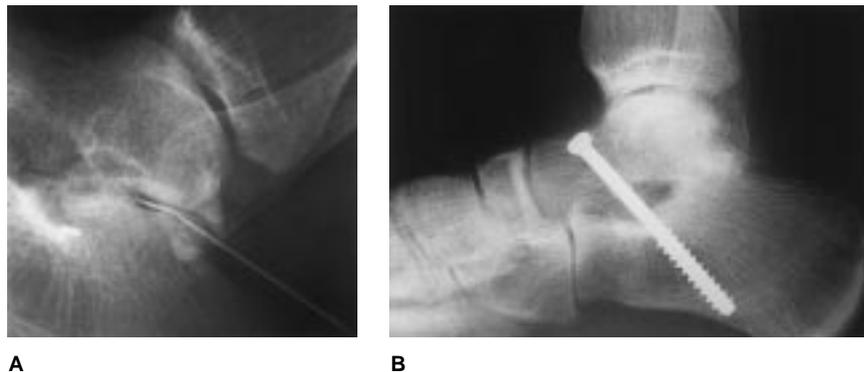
A, Fluoroscopically controlled anesthetic injection of the subtalar joint. The patient reported complete pain relief after the injection. B, A lateral radiograph demonstrates osseous union 1 year after a subtalar arthrodesis. The patient had excellent pain relief.
